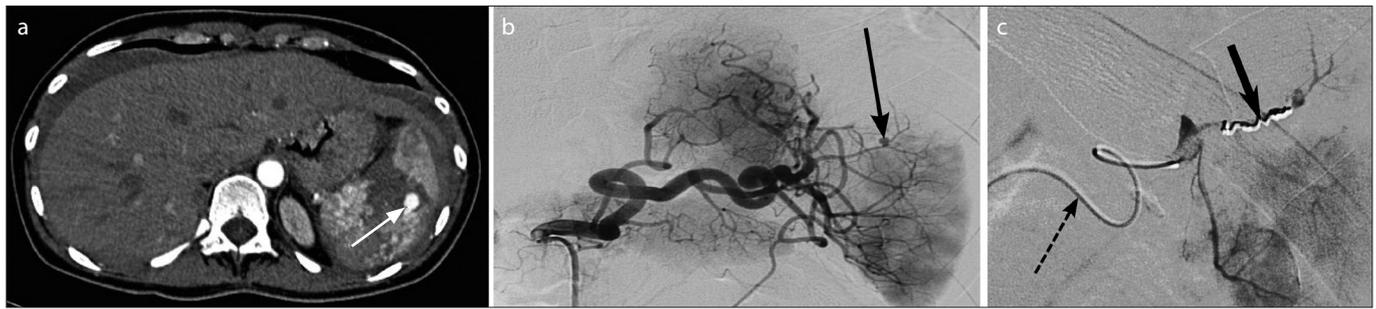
a–c. Distal embolization of a pseudoaneurysm. Transverse contrast-enhanced CT scan of the spleen at an arterial phase (a), shows a pseudoaneurysm (arrow) and a contusion of the superior pole of the spleen. Diagnostic arteriography of the splenic artery (b) confirms the intrasplenic pseudoaneurysm (arrow). Repeat arteriography with a microcatheter (dashed arrow, c) after distal embolization with a micro-coil (thick black arrow) of the parent artery.
